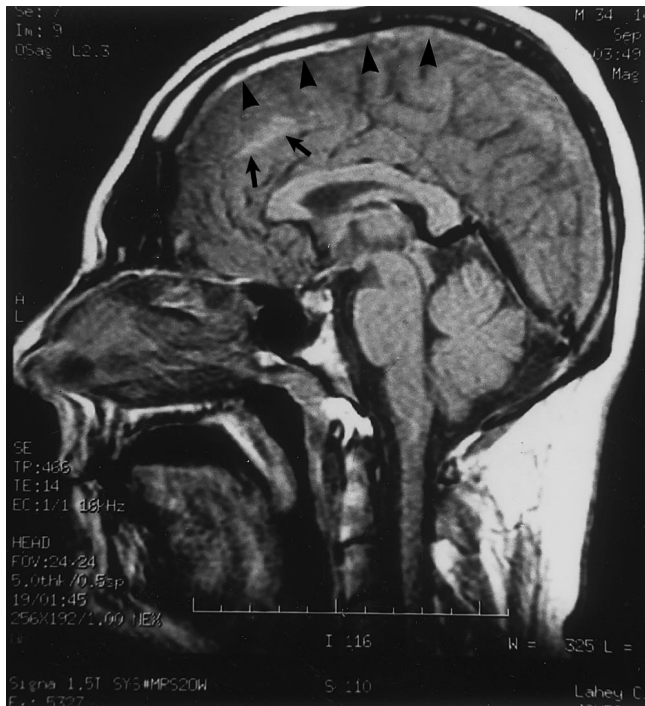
Sagittal midline MRI T1-weighted image showing absent flow void in the expected location of the SSS (arrowheads); signal characteristics represent hemorrhages in various stages of decay. Also shown is a right frontal hemorrhagic infarction (arrows).
